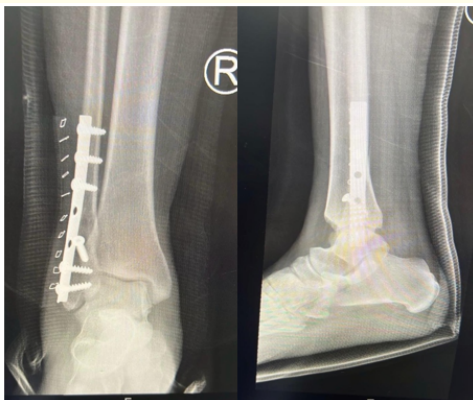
Anteroposterior and lateral radiographs of the right ankle obtained immediately postoperatively demonstrating open reduction and internal fixation of a distal fibula fracture using a lateral plate and screws. Alignment is satisfactory with appropriate hardware positioning and restoration of the ankle mortise.
